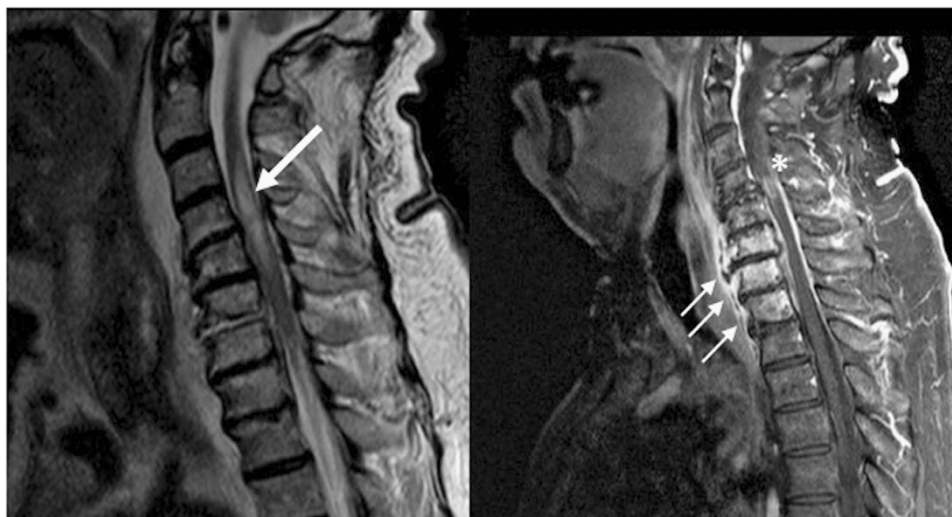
MRI demonstrating cervical myelitis and osteomyelitis. Left: T2-weighted image depicting a swollen spinal cord with increased intramedullary signal (arrow). Right: T1-weighted image with gadolinium showing gadolinium enhancement of the spinal cord (asterisk) and of the vertebral bodies and prevertebral tissue (arrows).
